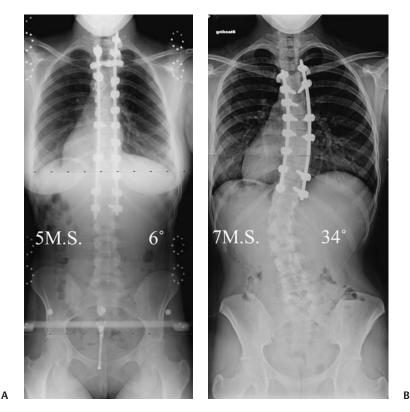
Two-year postoperative PA radiographs of patients with four different deformity-flexibility quotients (DFQ = residual lumbar deformity divided by number of unfused motion sequents).
